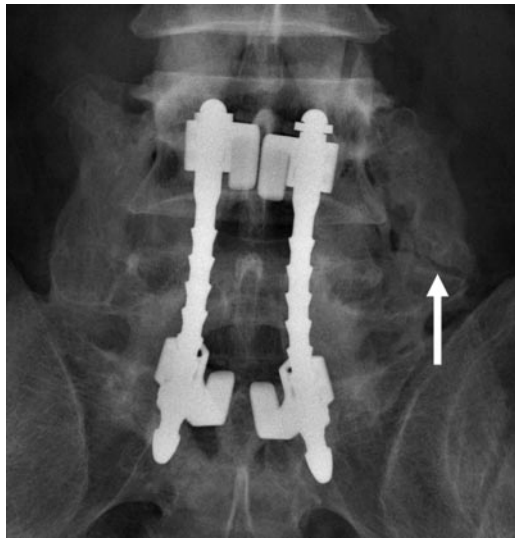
Mature pseudarthrosis in a symptomatic 54-year-old man who had undergone posterolateral fusion with Harrington rods from L4 through S1. Anteroposterior radiograph demonstrates a corticate linear defect in the posterolateral fusion complex on the left (arrow), a feature indicative of pseudarthrosis.
